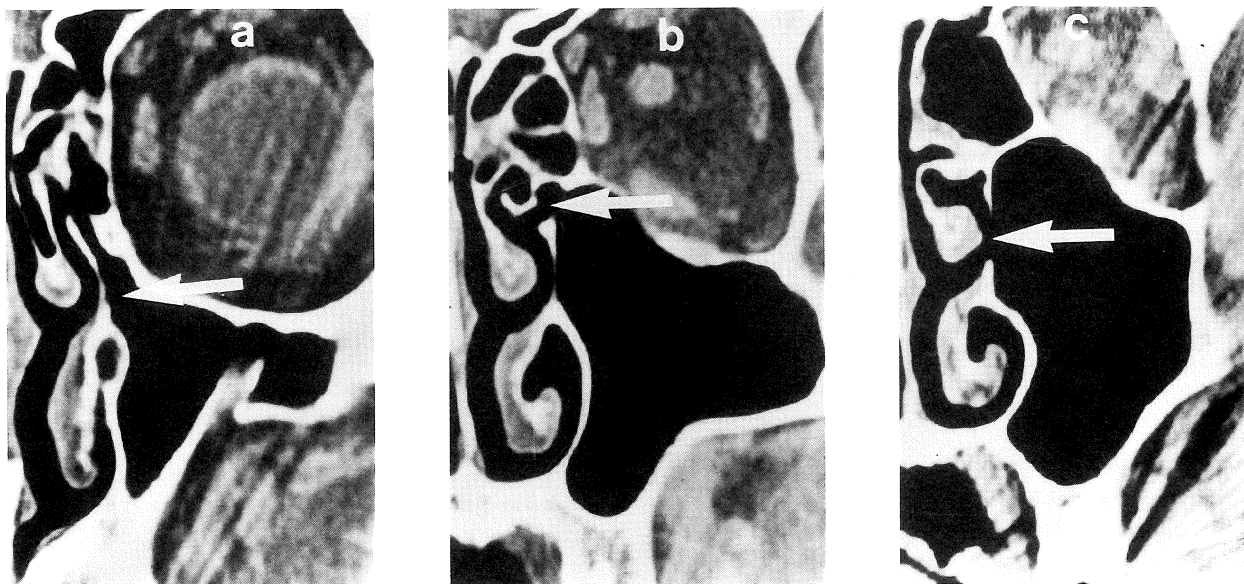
CT scan views of the maxillary sinus of a patient: *a*, the natural ostium opening into the infundibulum; *b*, an accessory ostium located posteriorly and superiorly on the medial wall of the sinus and emptying into the middle meatus; and *c*, a second accessory ostium located further posteriorly at the level of the middle turbinate and emptying into the nasal passage.
